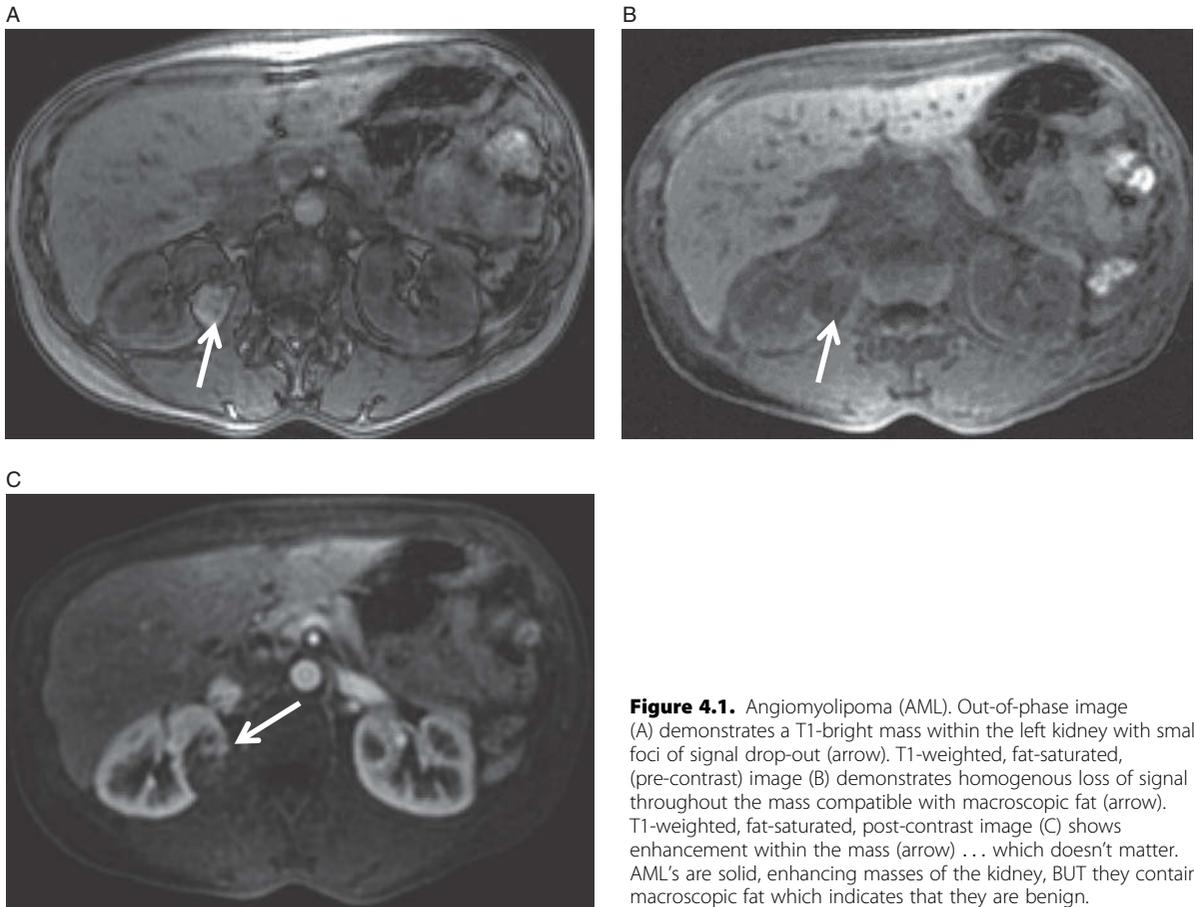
Angiomyolipoma (AML). Out-of-phase image (A) demonstrates a T1-bright mass within the left kidney with small foci of signal drop-out (arrow). T1-weighted, fat-saturated, (pre-contrast) image (B) demonstrates homogenous loss of signal throughout the mass compatible with macroscopic fat (arrow). T1-weighted, fat-saturated, post-contrast image (C) shows enhancement within the mass (arrow) . . . which doesn't matter. AML's are solid, enhancing masses of the kidney, BUT they contain macroscopic fat which indicates that they are benign.
